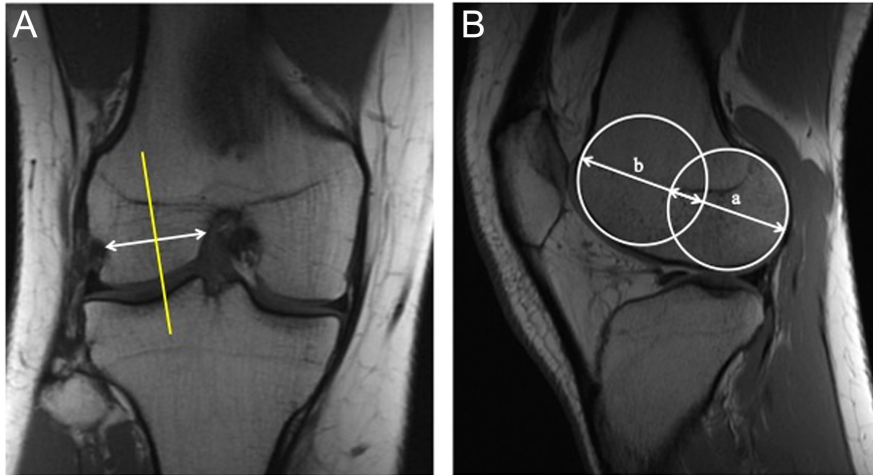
Lateral femoral condylar index measurement using MRI. (A) Coronal T1-weighted MRI image shows the reference axis for the middle of the lateral femoral condyle (yellow line) at the point where the popliteal groove is best visualized. (B) Sagittal T1-weighted MRI image in the plane of the reference yellow line is used to draw 2 circles: an anterior extension circle with the diameter “b” (6 and 9 o’clock position) and a posterior flexion circle with the diameter “a” (6 and 3 o’clock position). The lateral femoral condylar index is calculated by dividing diameters a/b. MRI, magnetic resonance imaging.
